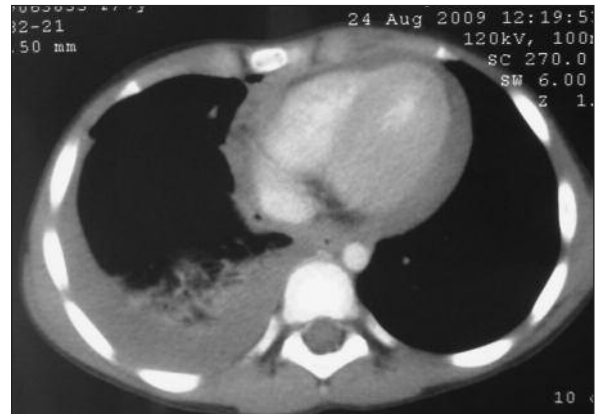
Chest computed tomography demonstrating pericardial blood.
